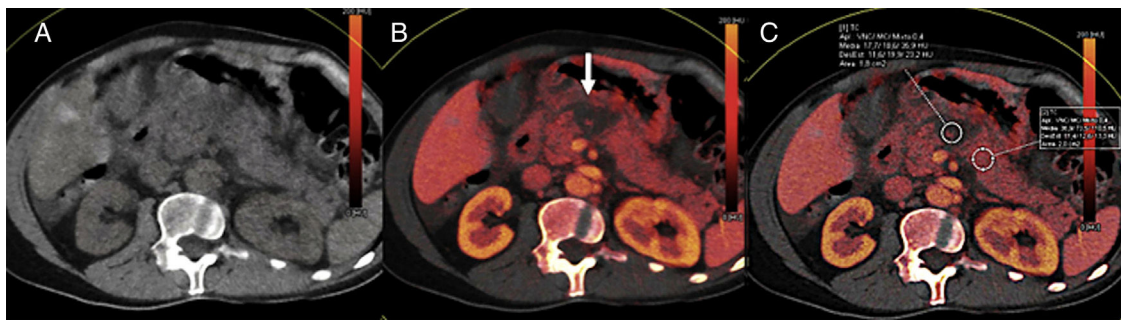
55-year-old male with acute pancreatitis. Computed tomography (CT) scan without contrast (A), color-coded iodine concentration map (B) and map with region of interest (ROI) measuring the concentration of iodine (C). The dual-energy computed tomography shows an area of necrosis at the level of the pancreatic body shown in the color-coded iodine concentration map as an area without iodinated contrast uptake (arrow) being the iodine quantified by placing one ROI in the gland parenchyma.
